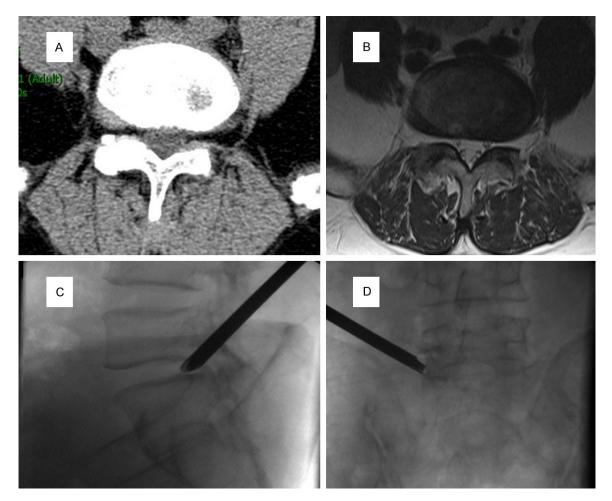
Preoperative PED images and radiographs of the lateral lumbar spine with position of the working catheter. A, B: Lumbar intervertebral disc CT and lumbar cross-sectional MRI suggested L5/S1 extraforaminal lumbar disc herniation; C, D: Position of working catheter.
